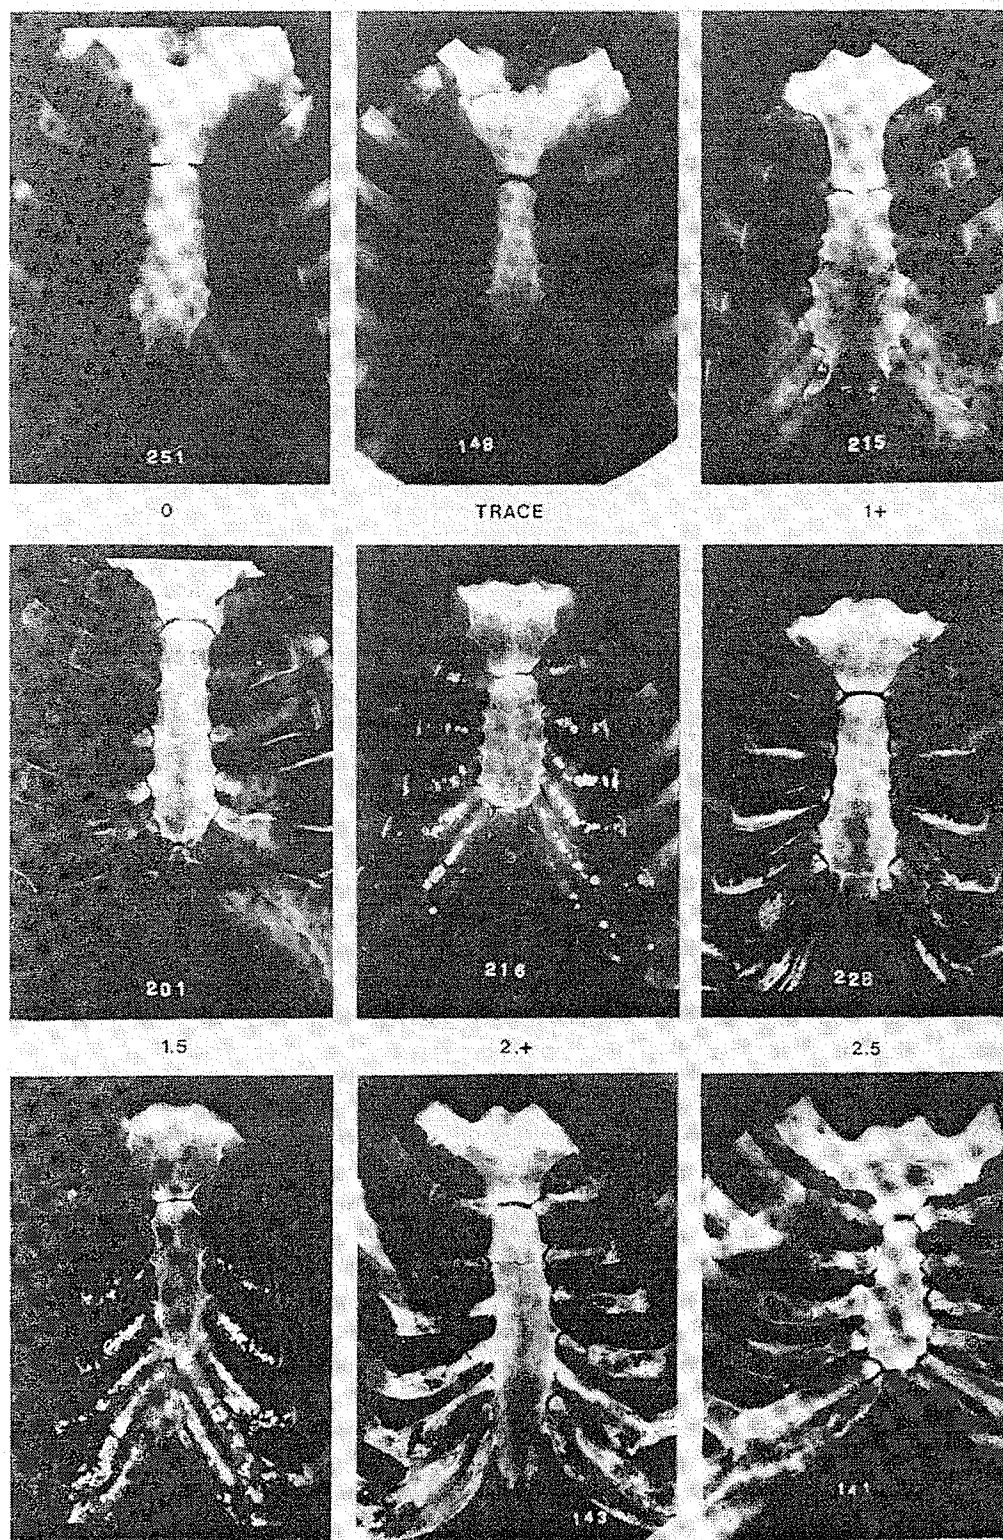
(Figure 1 in text): Template of chest plate radiographs with grading of ossification of costal cartilages.
